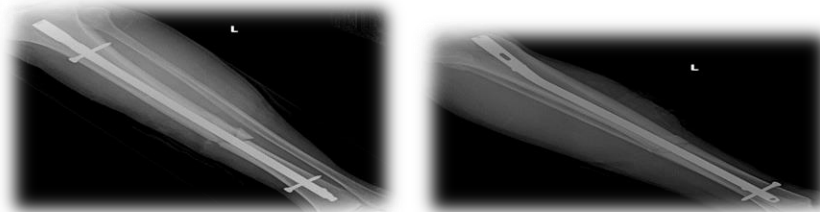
Postoperative radiograph of left tibial diaphyseal fracture showing buried Nail.
